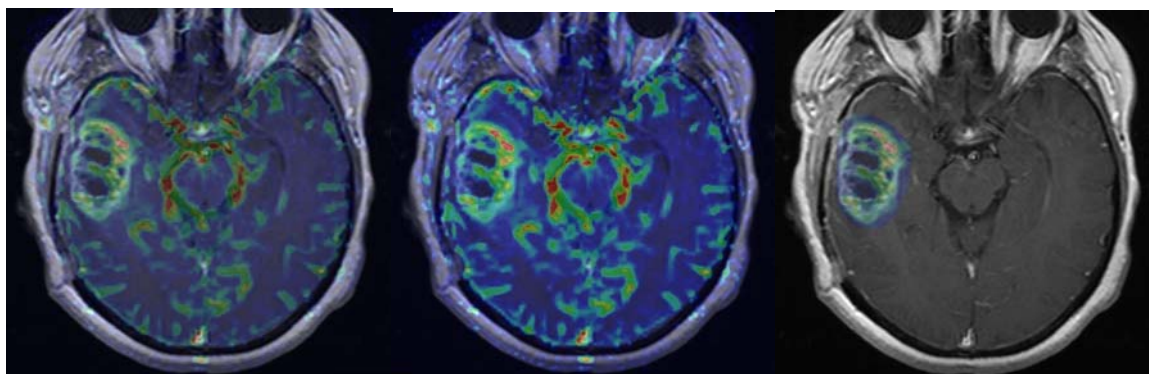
The multimodal visualization of T1-weighted image and regional CBF image. Global and local alpha blending results are presented (high perfusion in the tumor region)
